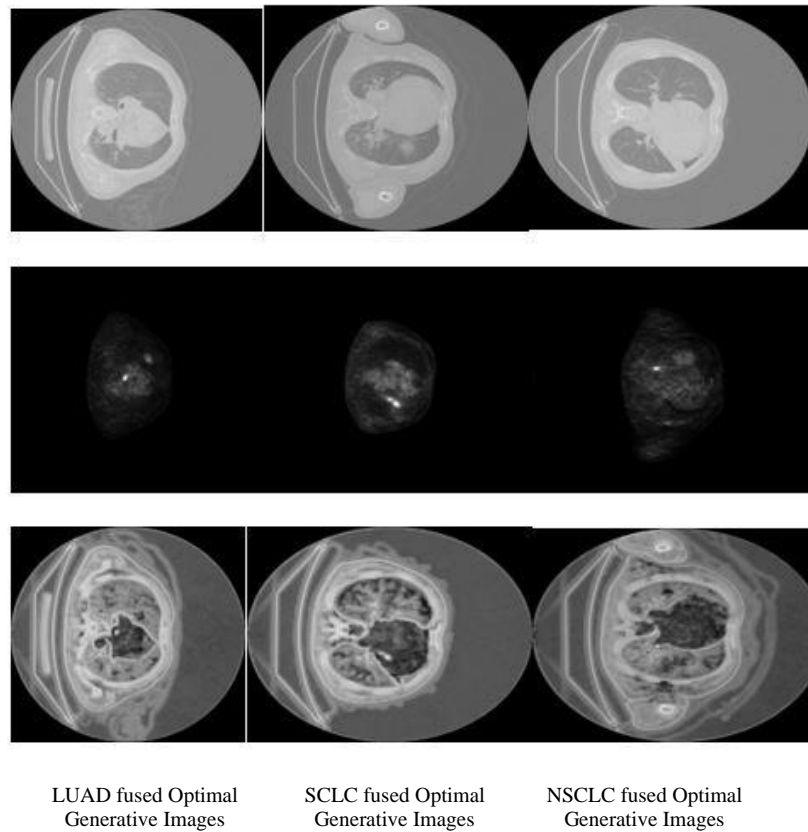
Correlating CT and PET slices out of disparate kinds of lung cancer. (i) NSCLC (ii) LUADC (iii) SCLC
